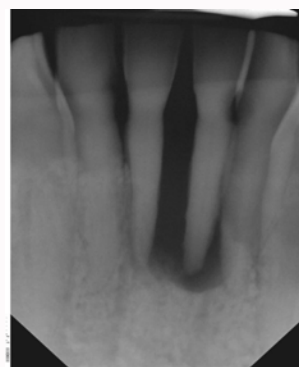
The X-Ray revealed total bone loss around his lower incisor which could have developed painful periodontal abscesses.
